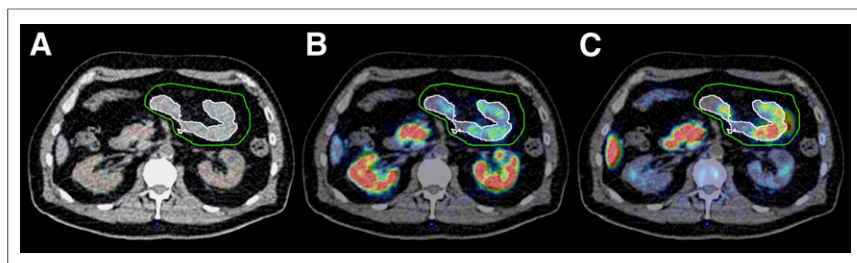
(A) Large PET VOI (green outline) included all radioactivity from intestines and stomach, respectively. To derive volume estimate, a VOI was segmented based on CT scan (white outline). (B) During early PET frames, radioactivity corresponded to anatomic outline. (C) At later PET frames, PET signal was displaced due to peristalsis but was included in large PET VOI.
